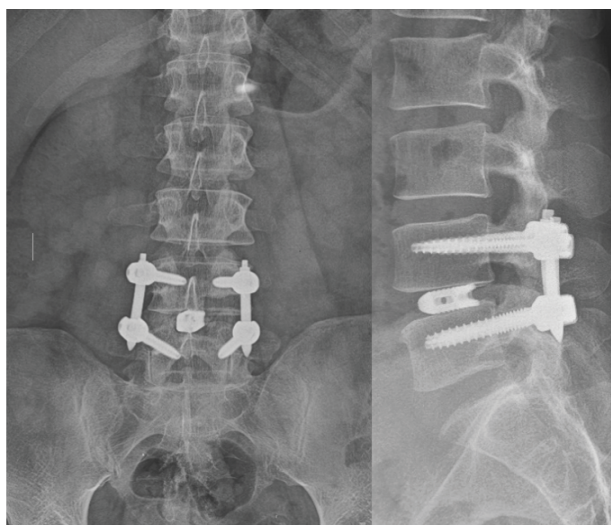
Post-operative Radiograph of MIS-TLIF fixation.
